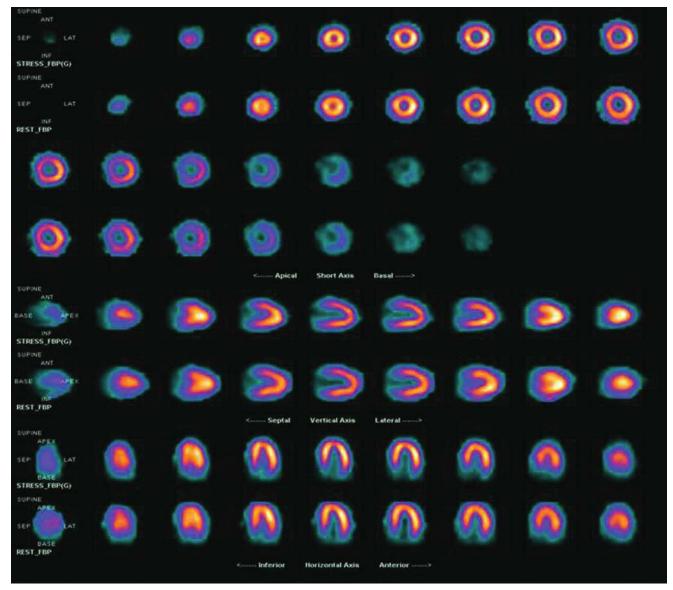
Myocardial perfusion imaging with exercise stress test in an 18-year-old female with Kawasaki disease and left anterior descending artery coronary aneurysm presenting with chest pain. The patient, exercised according to the Bruce protocol for 12 minutes, achieved 100% of the maximal, age-predicted heart rate. No scintigraphic evidence of stress-induced ischemia or prior myocardial infarction was found.
